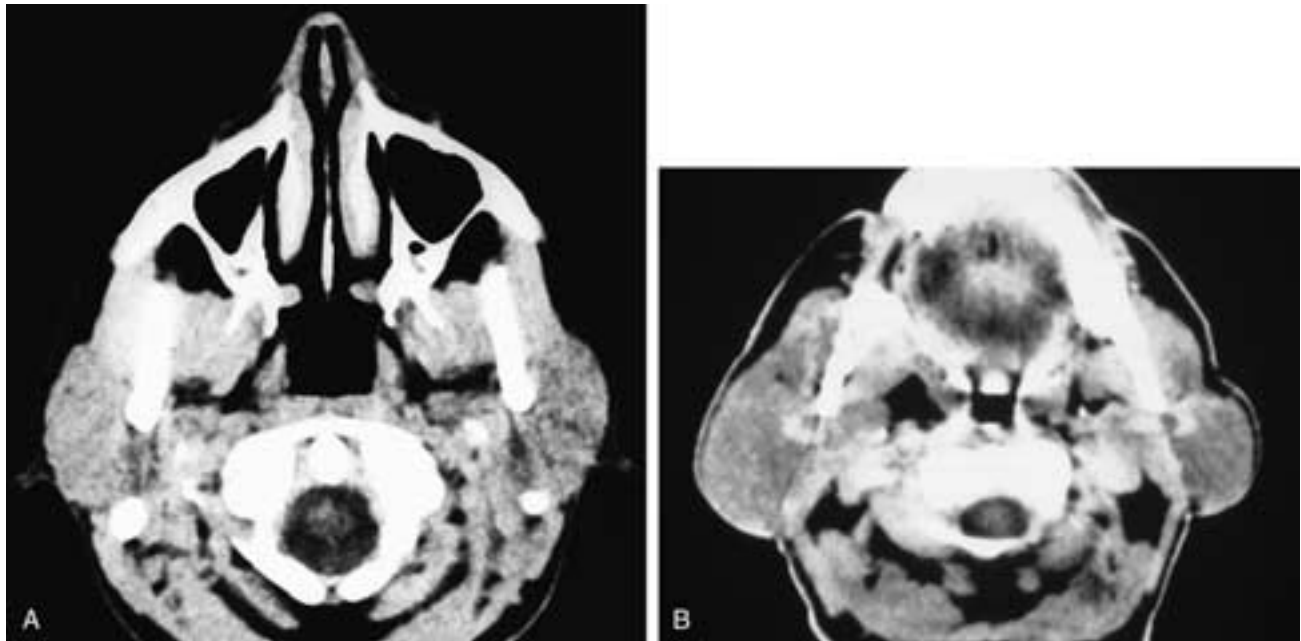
Axial CT scans (A, B) on two different patients. Both patients have enlarged and minimally dense parotid glands. This is a nonspecific finding. These patients had sialosis.
